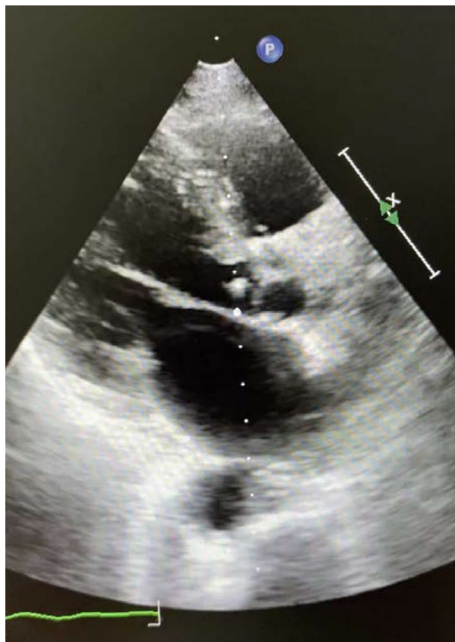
Two-dimensional (2D) echocardiography, Long axis, mobile aortic valve vegetation
